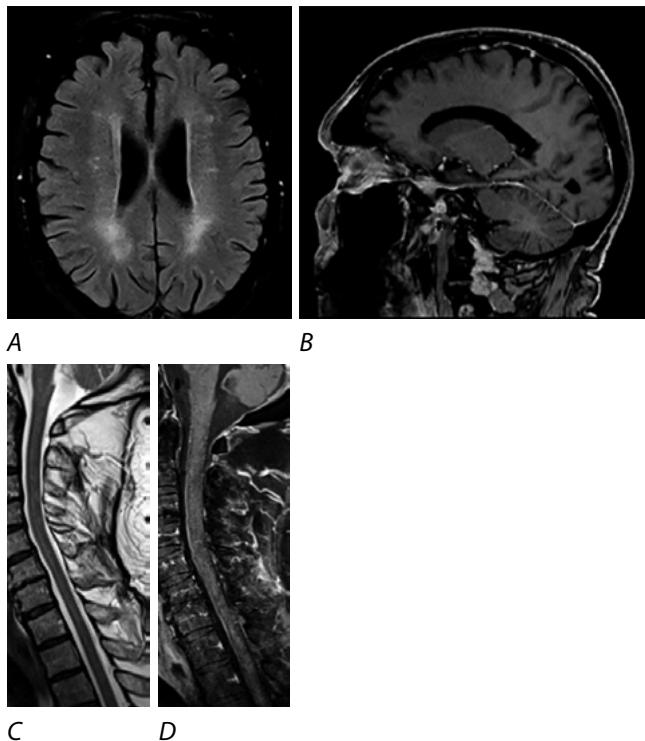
Patient M.'s brain and spinal cord MRI (December 2021). A, C – T2-FLAIR/T2-STIR: partially resolved focal changes in the brain and spinal cord. B, D – T1+C: no abnormal enhancement in the brain matter; decreased volume and intensity of abnormal enhancement in the spinal cord.
